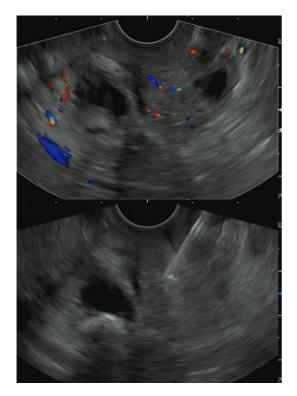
Endoscopic ultrasonography (EUS) and EUS-guided fine needle biopsy (EUS-FNB) images. (Top) An EUS image demonstrating a slight echogeneous mass of 11 mm in diameter with a vasculature signal. The lesion was contiguous to the duodenal submucosal layer. The muscular layer at the base of the mass was thickened. (Bottom) An EUS image obtained during EUS-FNB with a 22-gauge Franseen needle.
